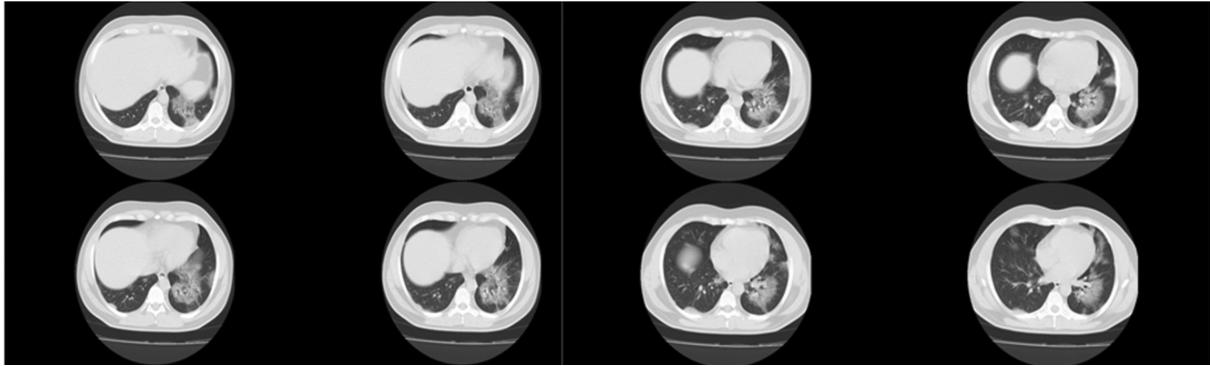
Base line axial thorax computed tomography showing multiple bilateral ground-glass patchy opacities and subpleural effusion in both lungs, particularly in the upper lobe, with a fibrotic appearance in the left lung.
